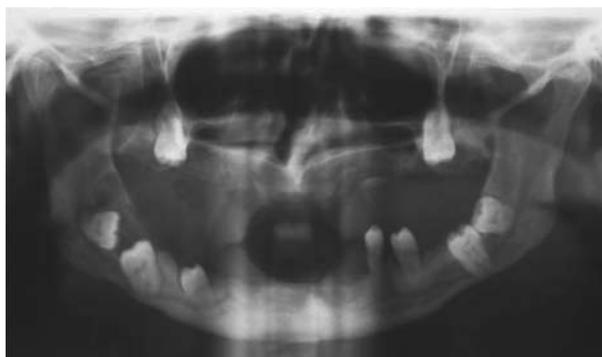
Orthopantomograph Patient 3.
